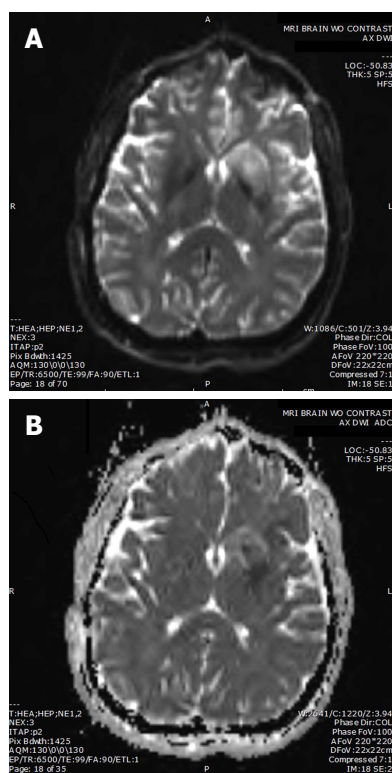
Ten hours post procedure imaging demonstrating small left subcortical infarct. A: Post procedure diffusion weighted magnetic resonance imaging; B: Post procedure apparent diffusion coefficient.
